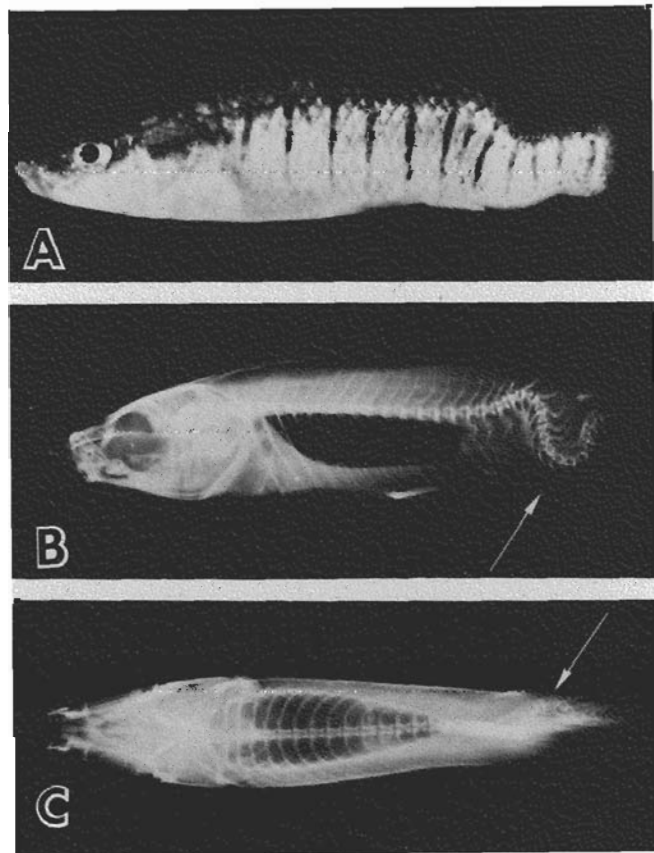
Fundulus similis* from Escambia County, Florida. (A) Lateral view reveals anomalous morphology. (B) Radiograph reveals the extreme lordotic condition and slight rotation of vertebrae on their central axis. (C) Radiograph shows a lateral curvature (scoliosis) of the posterior caudal vertebrae (arrow).
